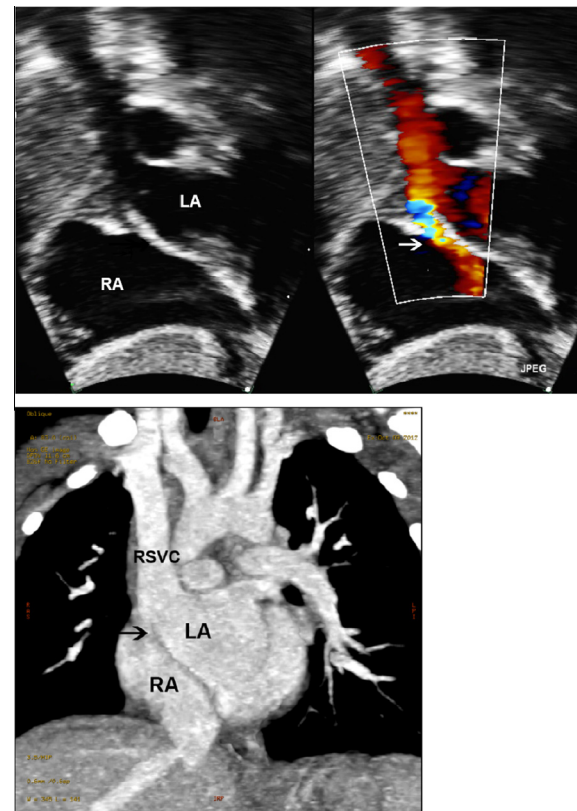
Two-dimensional (2D) echocardiography (upper left image) with Color Doppler Flow (upper right image) from subcostal views in comparison with cardiac CT findings at same plane (lower image): The right SVC is seen draining into left atrium with a small sinus venosus type ASD (arrow). LA indicates left atrium; RA, right atrium; RSVC, right superior vena cava.
